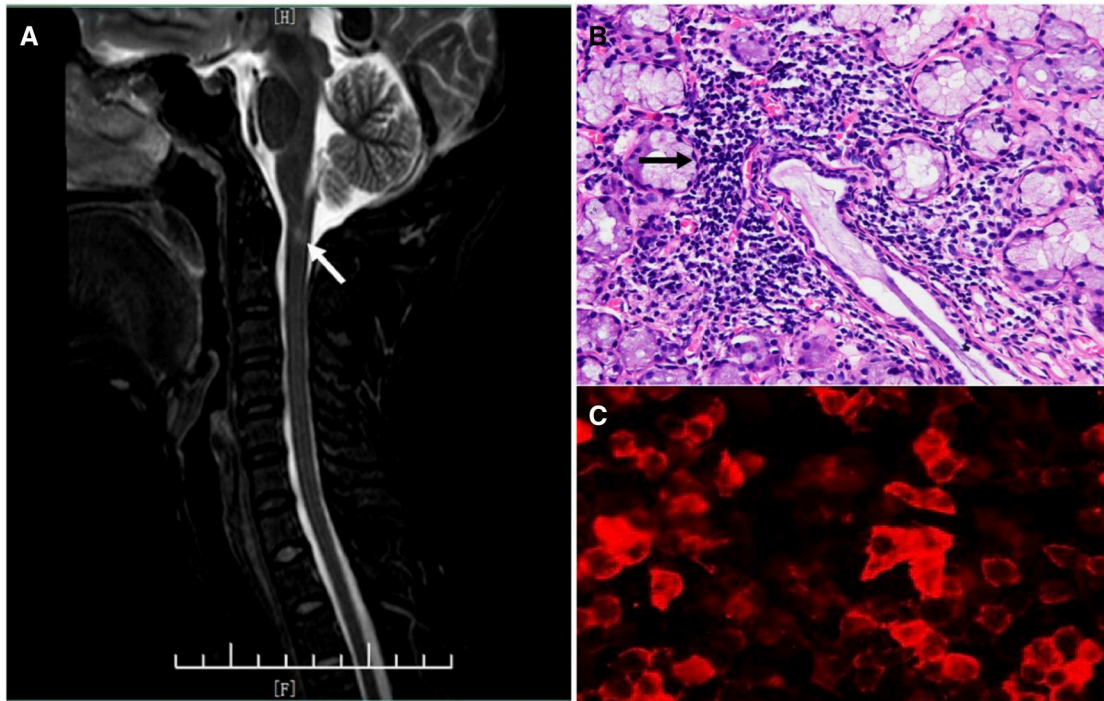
Imaging and biopsy results of the patient with NMOSD secondary to pSS. (A) Cervical medullary MRI showed a hypersignal lesion in the T2 sequence at the C2 level (highlighted by an arrow). (B) Lip biopsy showed focal collection of lymphocytes (highlighted by an arrow). (C) Serum anti-aquaporin-4 (AQP4) antibody test was positive by using cytometric bead array
